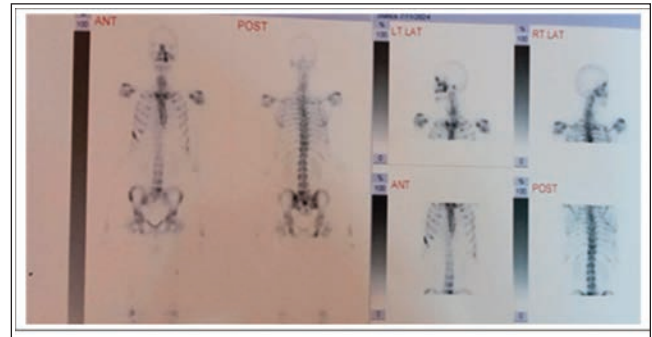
Radionuclide whole body skeletal survey showing bone metastases (bone scintigraphy).
